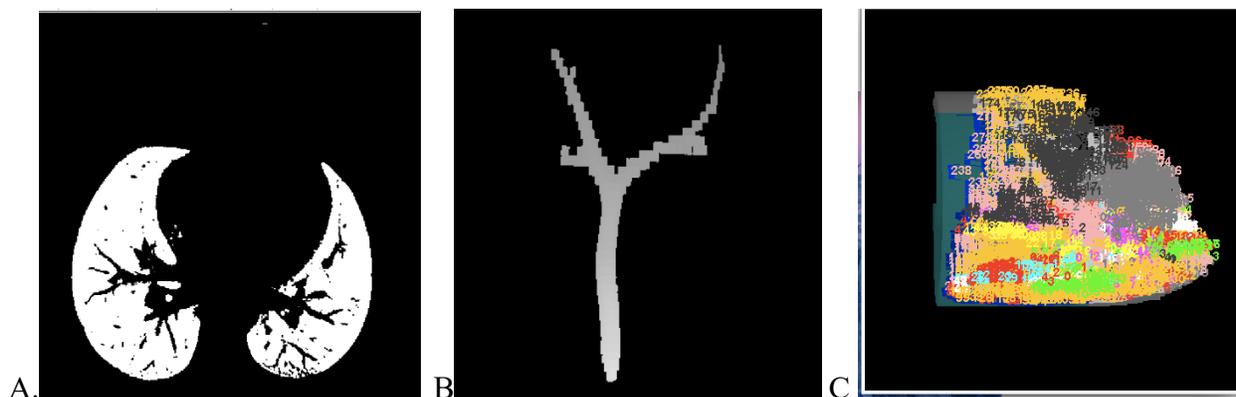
Process for extracting the lung vasculature structure. Shown are representative images obtained from a 4 years 10 months old full-term pediatric patient. Image A (left) shows the lung mask from a single chest CT slice, image B (middle) is a depiction of the extracted major airway, and image C (right) represented skeletonized and numbered pulmonary tree structure where each vessel tree is shown in a unique color.
